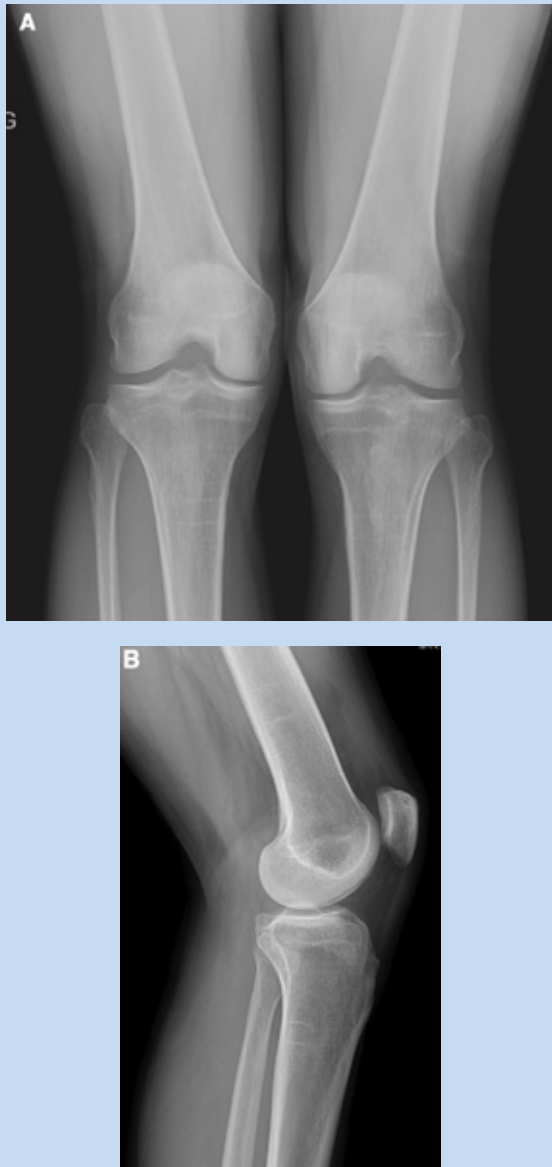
A, preoperative bilateral knee flexion weightbearing radiograph, revealing no osseous abnormalities; B, preoperative lateral knee radiograph, revealing no osseous abnormalities.
